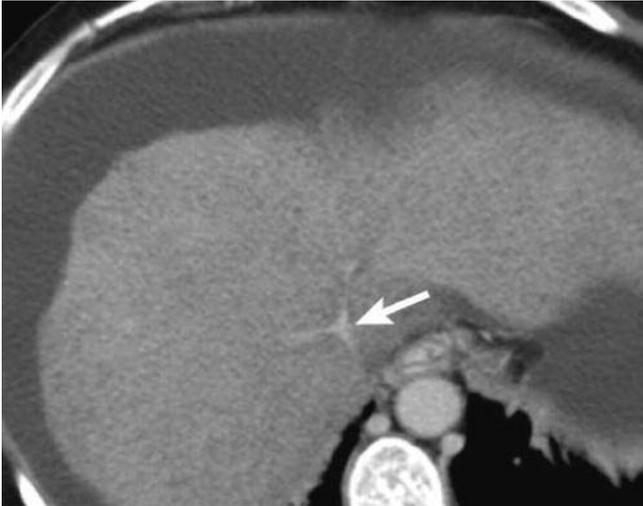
CT scan of the liver post I-V contrast demonstrates stenosis of the IVC.
